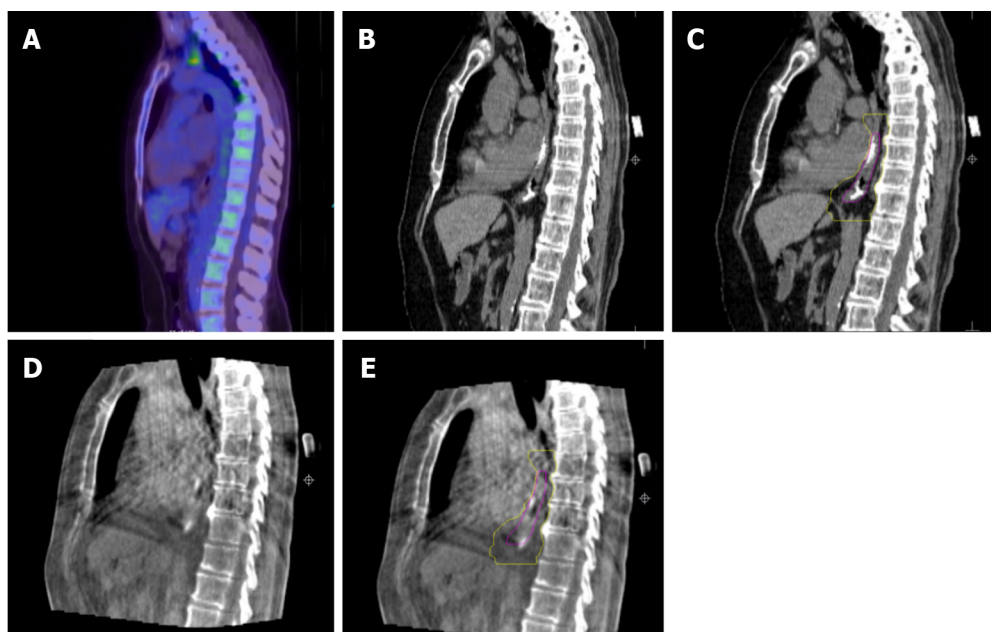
Endoscopically inserted liquid fiducials and liquid fiducial-based image-guided radiotherapy. A: An Fluorodeoxyglucose positron emission tomography of a patient with oesophageal cancer which demonstrates no uptake within the lesion; B: Planning computerized tomography (CTs) showing the fiducials without and with the high dose clinical target volume (CTV) (pink); C: Planning CTs showing the fiducials without and with the low dose CTV (yellow); D: Cone-beam CT (CBCT) images that are not labelled; E: CBCT images that are labelled.
